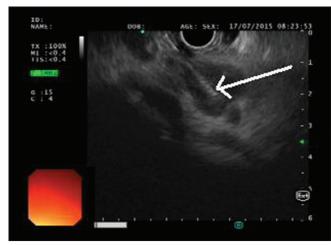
Endoscopic ultrasound image showing enlarged, hypoechoic lymph node along the inferomedial wall of second part of duodenum being sampled
